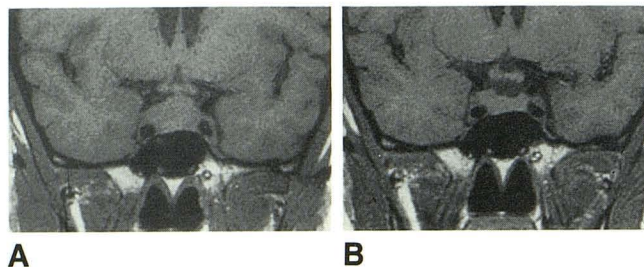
A, T1-weighted (600/20) coronal MR image shows diffusely enlarged pituitary gland consistent with macroadenoma or hyperplasia. B, T1-weighted MR image at same level as A obtained after 3 months of thyroid hormone replacement shows normal-sized pituitary gland. Note that right side of gland is larger than left side. This is thought to represent asymmetric regression of a hyperplastic gland.
